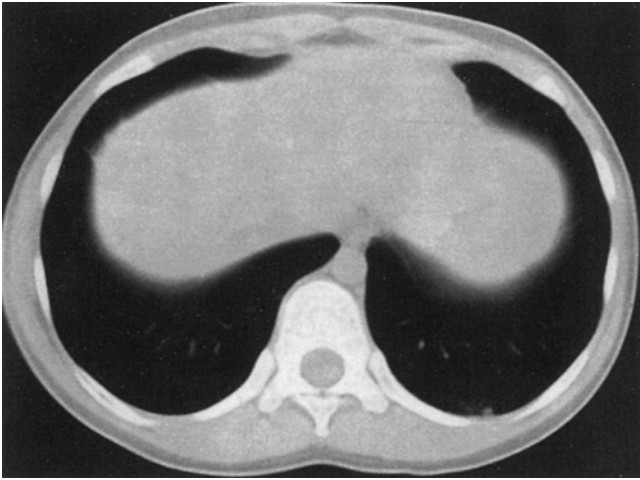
CT scan chest showing multiple subpleural and parenchymal metastases
